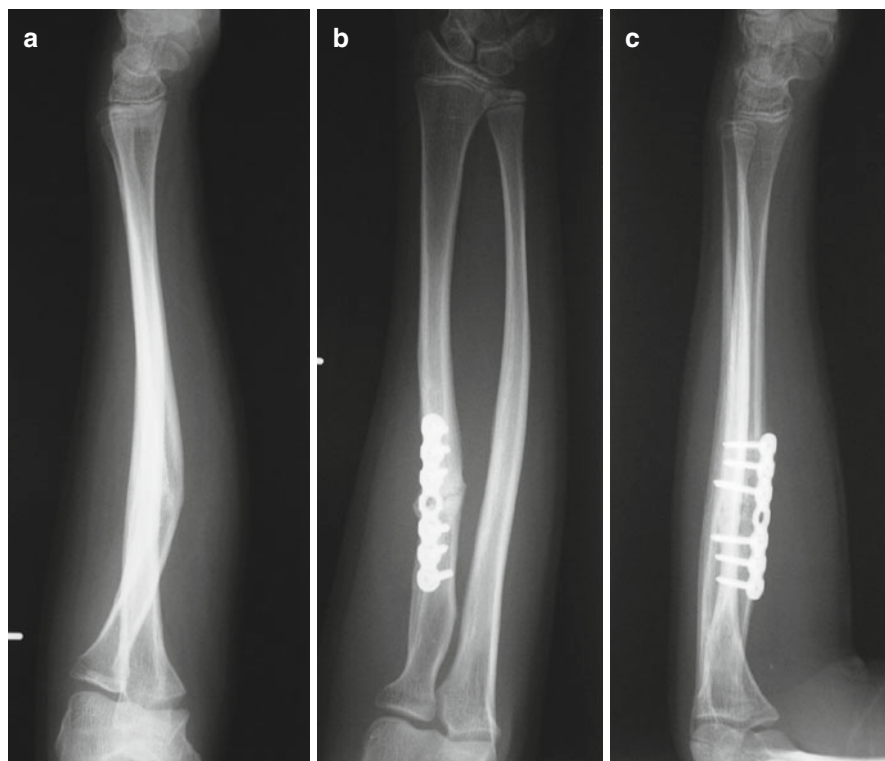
A preoperative radiograph of a 13-year-old boy with malunited diaphyseal fracture of the radius who complained restricted forearm supination. The radius showed a 25° angular deformity at the middle third (a). The postoperative AP (b) and lateral (c) radiographs show good anatomical correction
